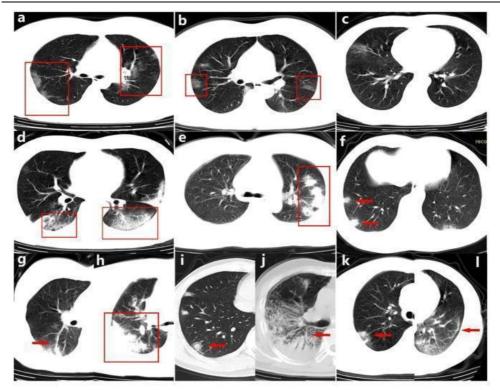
Chest CT scan features of COVID-19. a-b. GGO. c. GGN. d. Crazy Paving Pattern. e. Long Axis Parallelism. f. Patchy Ground-glass Opacities. g. Increased Vascular Margins. h. Consolidation. i. Nodule with Halo Sign. j. Air Bronchogram. k. Reversed Halo Sign. I. Parenchymal Bands (Luo *et al.*, 2020).
